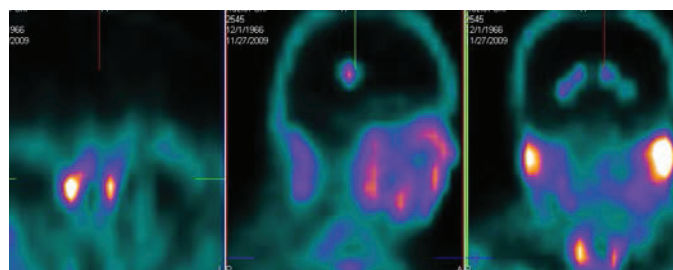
SPECT with ^{99m}Tc -MIBI. The patient with chronic hyperplastic laryngitis. There is no accumulation of the radiopharmaceutical in the projection of the larynx
